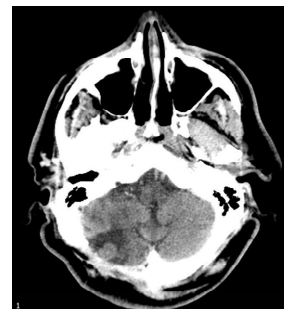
A non contrast enhanced computed tomography, 2005.
